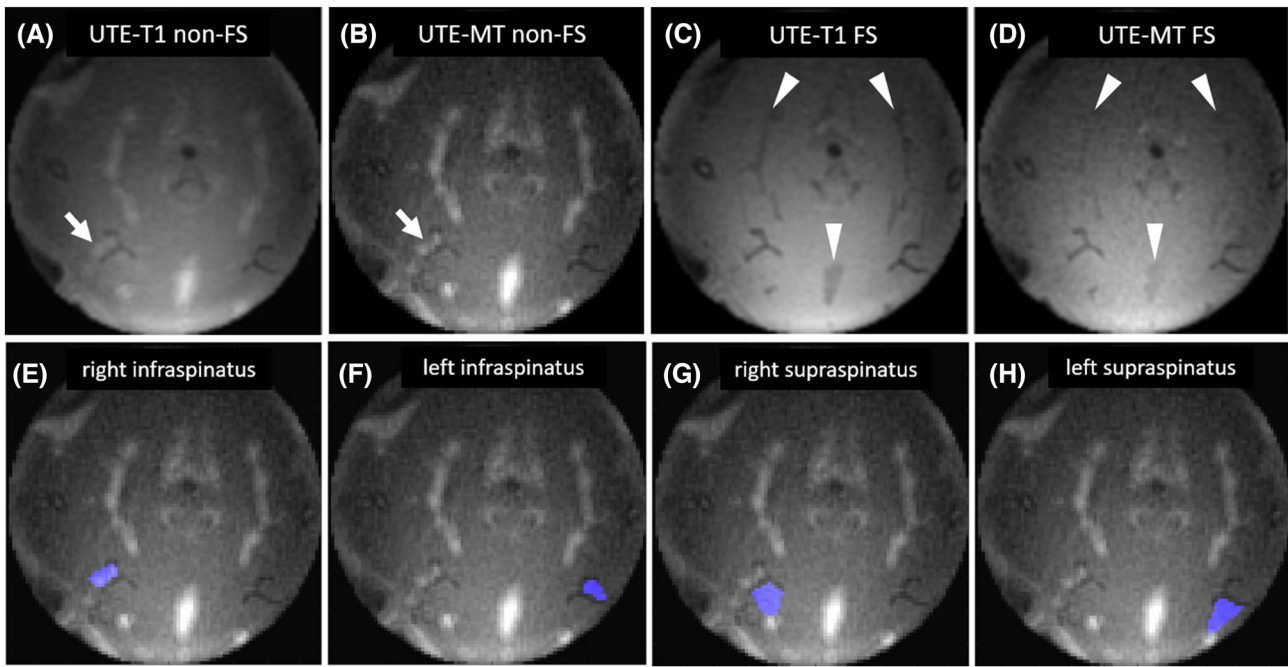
Representative source images (A–D) and regions of interest (E–H) used for quantitative UTE magnetic resonance imaging (UTE MRI). Regions of interest over the muscles (purple areas in E–H) were drawn with rapid imaging with refocused echoes (RARE) images as an extra guide (not shown). On the non-FS images, foci of high signal intensity are identified on the injured right sides (arrows in A and B). Fat is effectively suppressed on the FS UTE images, including the intermuscular fat (arrowheads in C and D). FS, fat suppression; UTE-MT, ultrashort echo time magnetization transfer.
